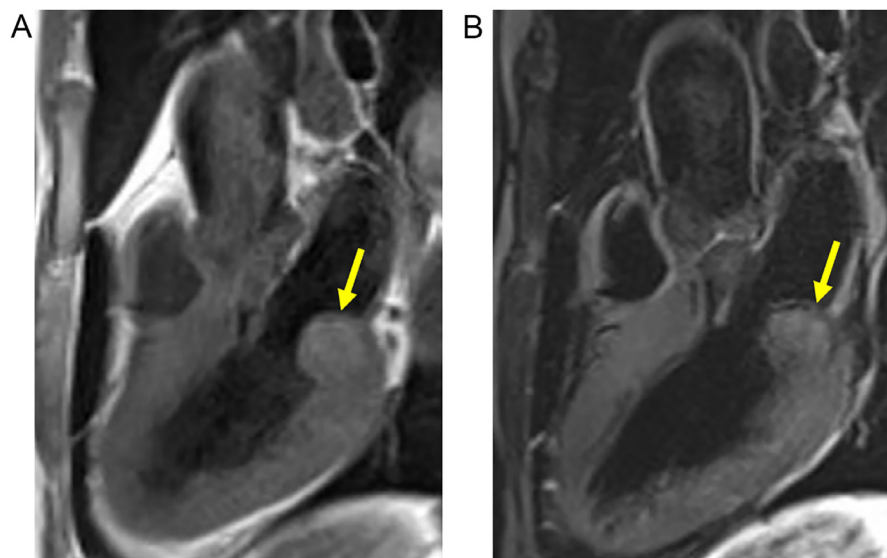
Cardiac MRI reveals that the mass has an isointense signal compared to the myocardium on T1-weighted sequences and fat-suppressed T2-weighted sequences.
